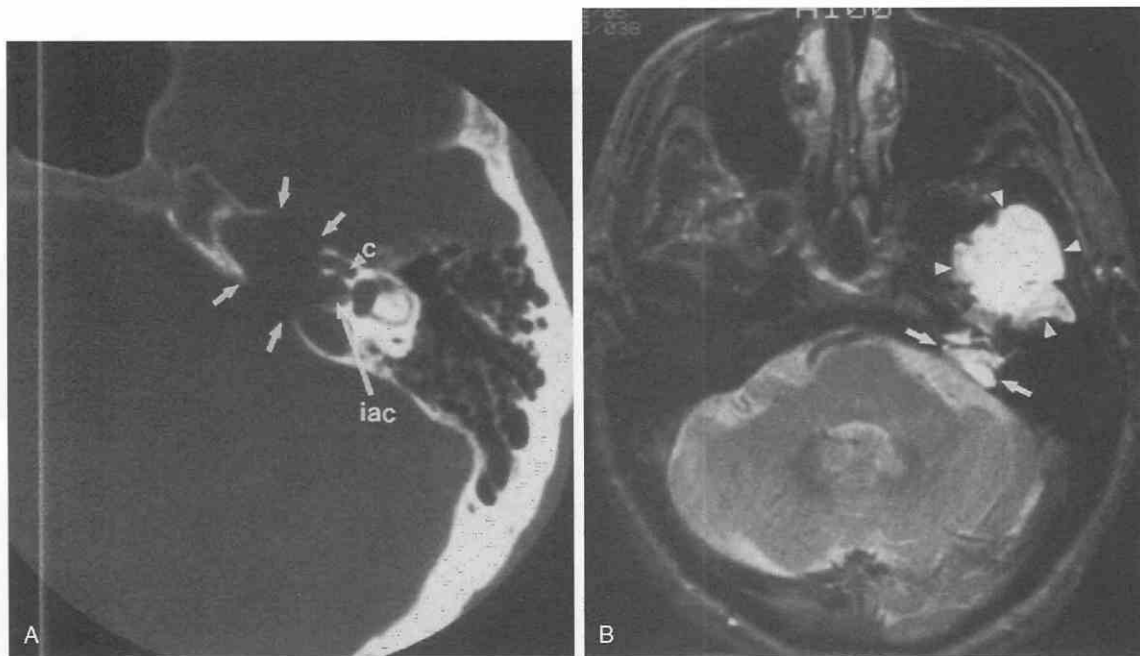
Epidermoid of the petrous apex in a 40-year-old man presenting with symptoms similar to those of an acoustic schwannoma. *A*, Axial CT image through the left internal auditory canal shows a large destructive lesion (arrows) involving the petrous apex, internal auditory canal (iac), and cochlea (c). The lesion is rather sharply margined. The mastoid and middle ear are intact. *B*, Axial T2-weighted MR image demonstrates that the lesion has a very high signal (consistent with a high water content). One component is within the petrous apex (arrows), and a second larger area involves the anterior portion of the middle cranial cavity (arrowheads). There is little reaction of the adjacent brain.
